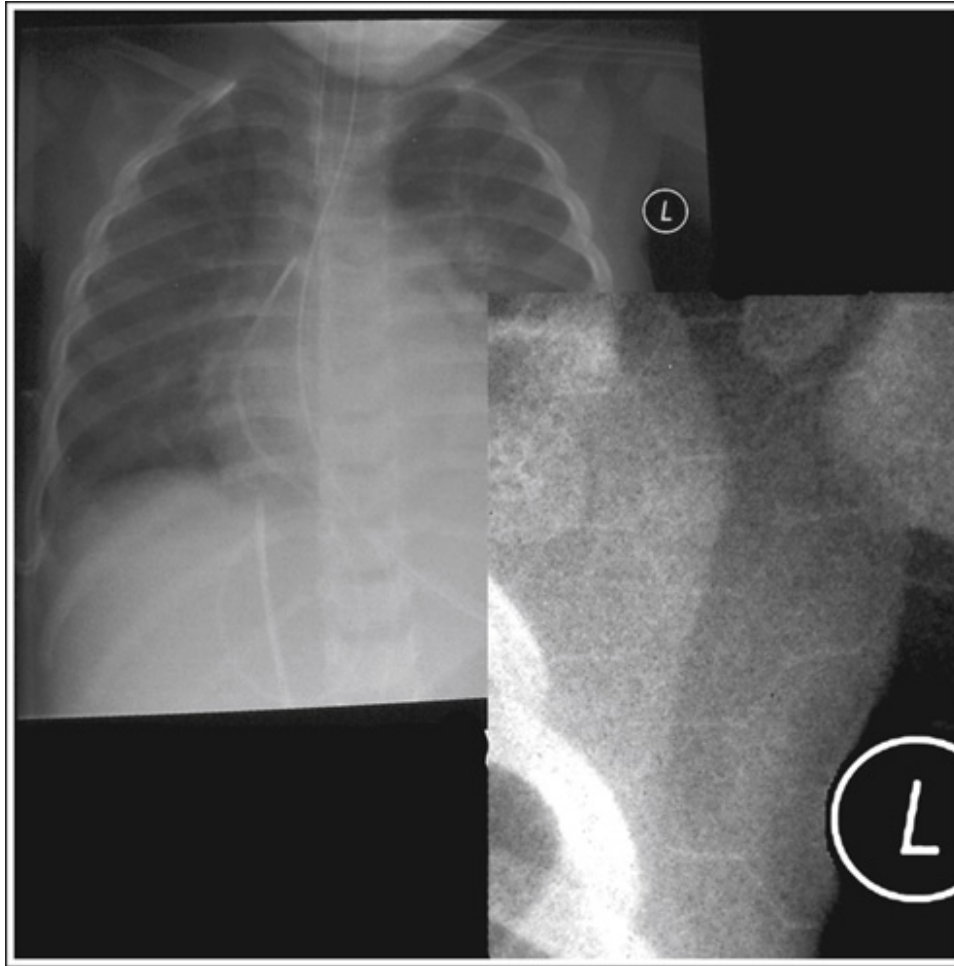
Computed radiography AP chest projection demonstrating honeycomb pattern overlying the projection. This was caused by the back of the cassette being positioned toward the CR for the exposure.
